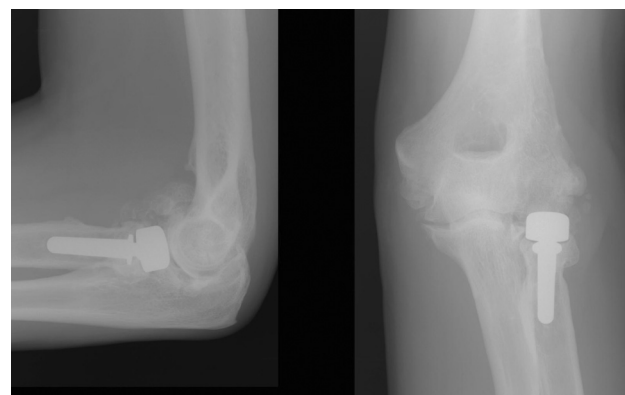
Radiographs taken 10 years after implantation of a Guepar® bipolar radial head prosthesis.
